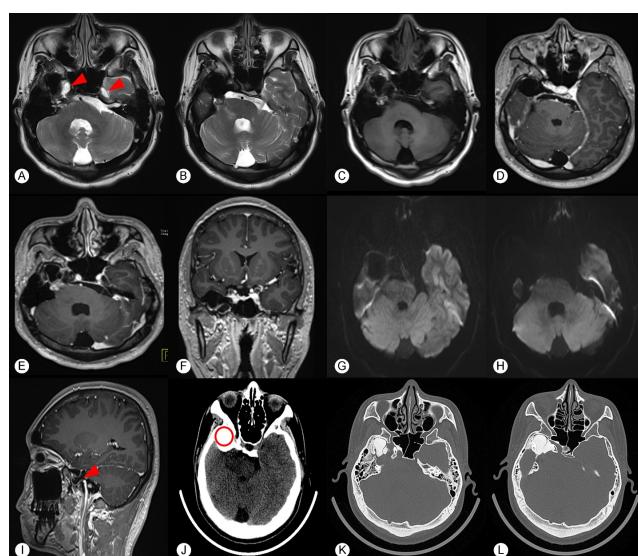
The preoperative imaging data of Case 2. (A)~(C): MRI scan indicates a mass in the right middle skull base, with low signal intensity in T1 and T2. The brainstem is displaced to the right side, and the red arrow indicates abnormal high signal intensity in both middle skull bases. (D)~(F): The enhanced MRI scan shows no enhancement in the middle skull base mass. (G) and (H): DWI sequence of MRI. (I): MRI T1 weighted imaging sagittal plane. The red arrow corresponds to the abnormal fluid signal in the middle skull base on the right side of figure A. (J) and (K): Brain CT scan and bone window
